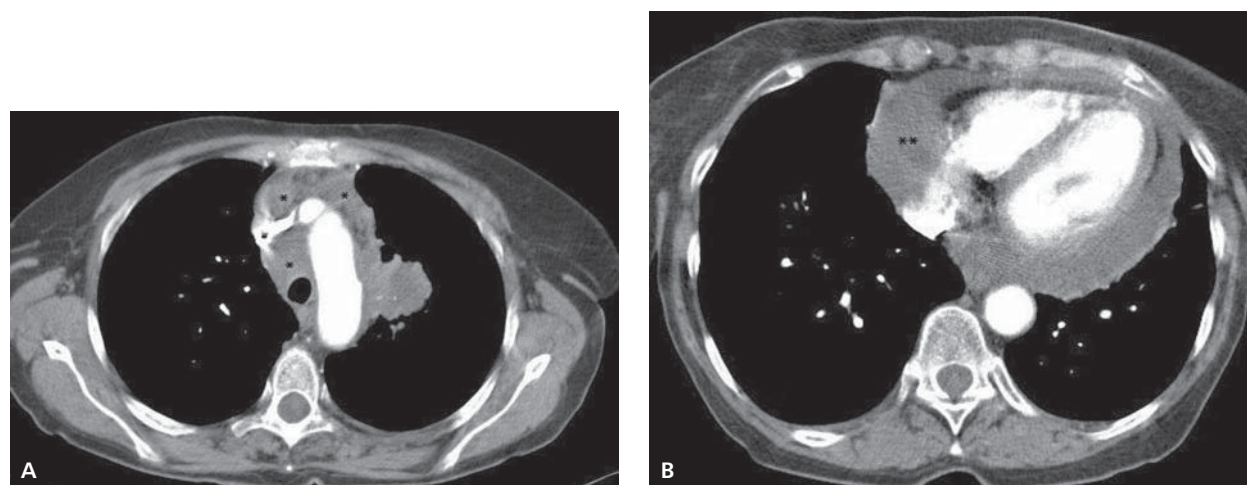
L.M., a 62-year-old women. Chest computed tomography with contrast enhancement, mediastinal window; A. Lung tumour in the left upper lobe. Enlarged mediastinal nodes are also seen (*); B. Pericardial effusion ()
